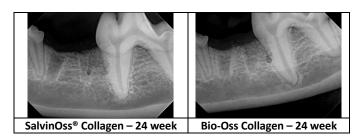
Radiographic Images of SalvinOss® Collagen & Bio-Oss Collagen® at 24 Weeks
